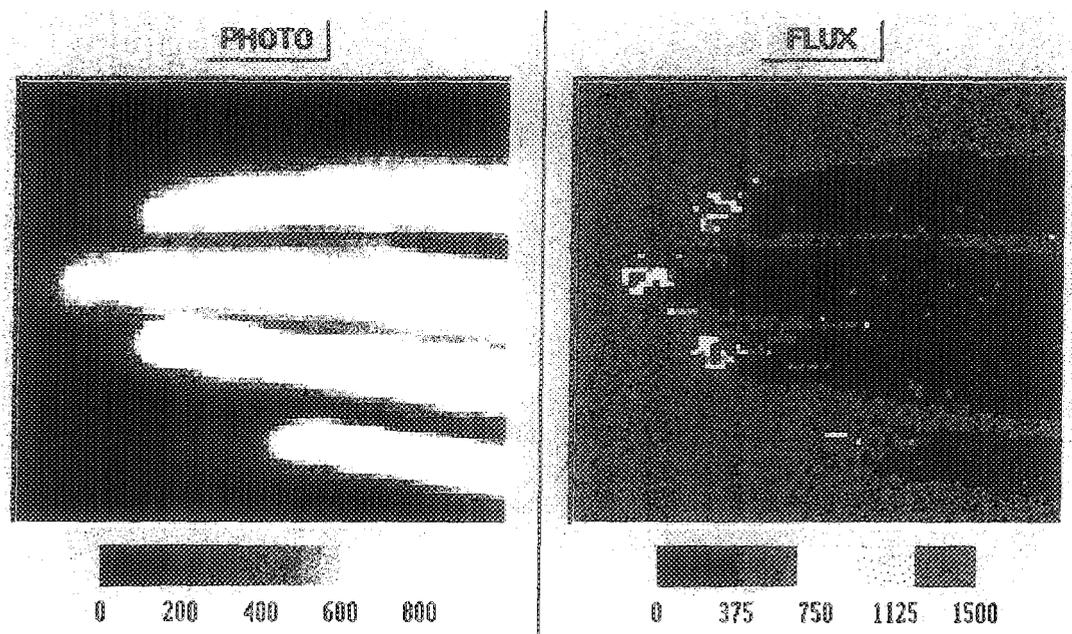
Photo and Laser Doppler Images Obtained by the moorLDI
